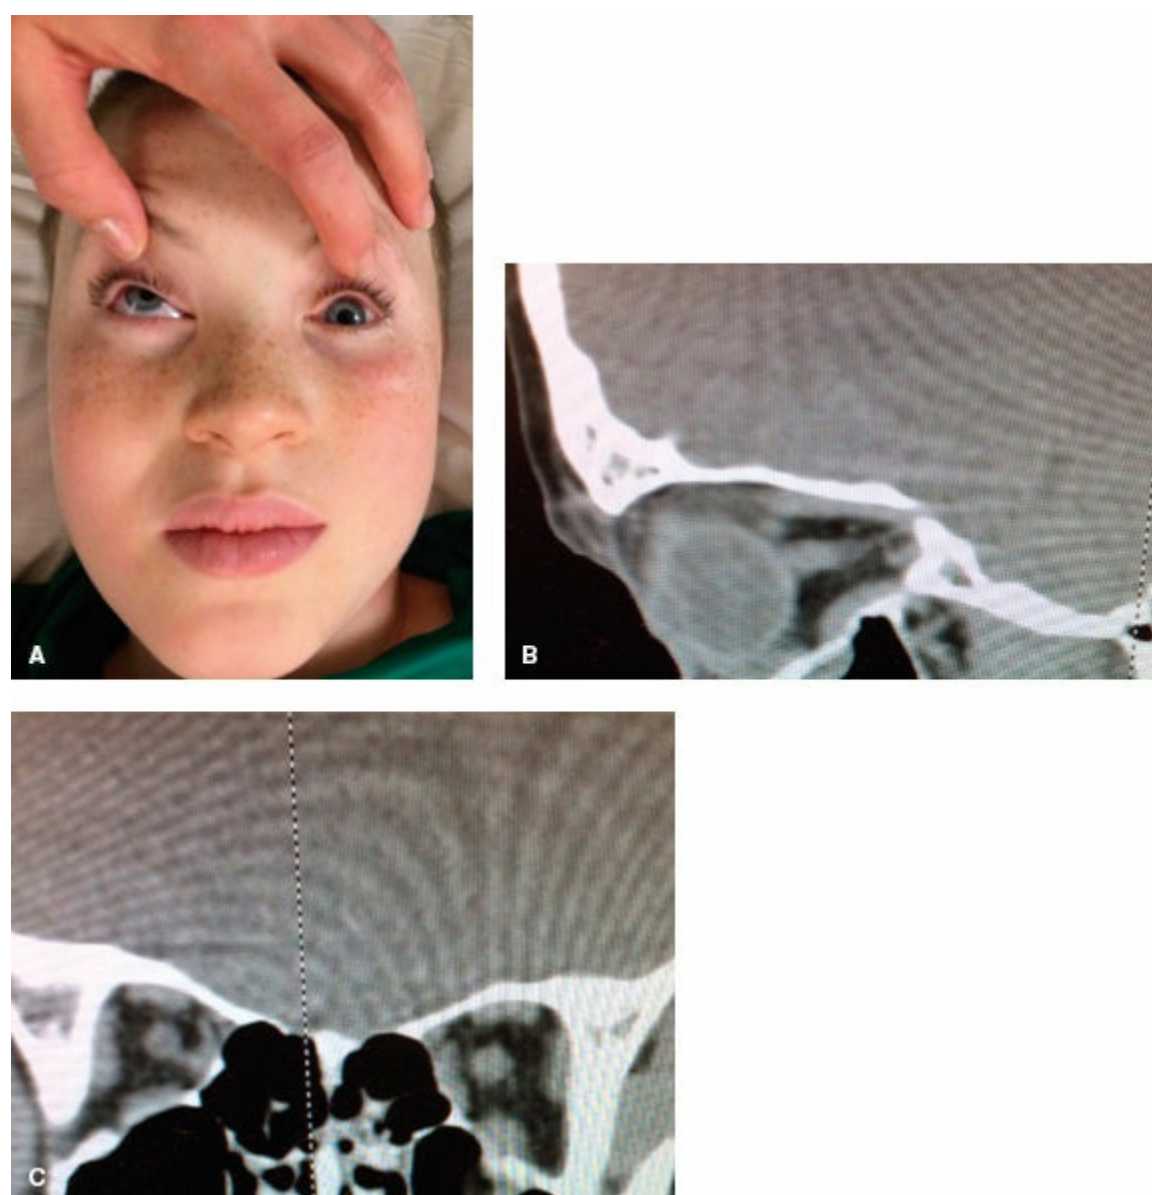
A different patient who sustained a left orbital floor blow-out fracture with entrapment of the inferior rectus muscle. A: Clinical photo demonstrating limitation of upward gaze. B: Sagittal reformat of CT showing entrapment of left inferior rectus. C: Coronal reformat showing the same.
